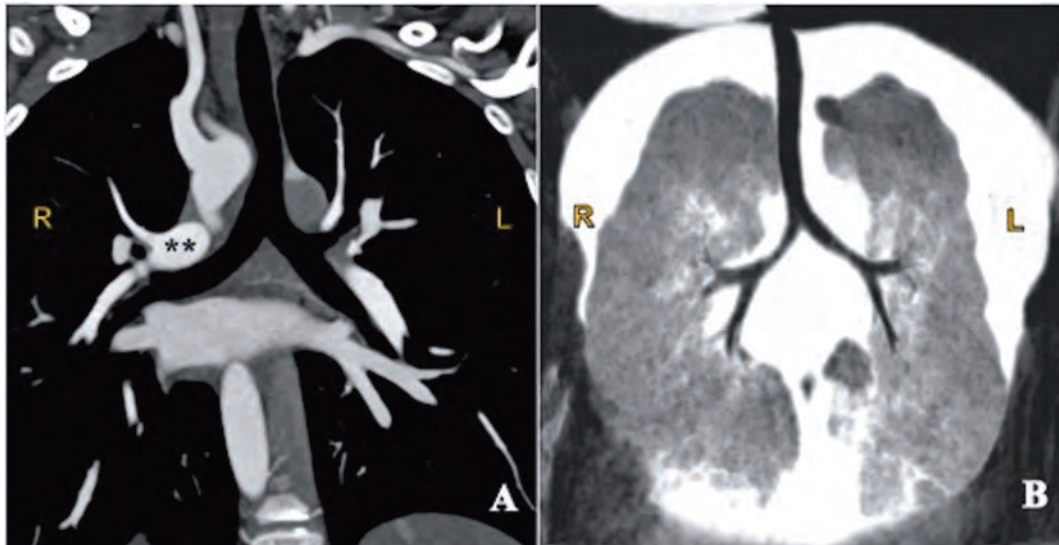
A) CT reconstruction shows right hypoarterial bronchus (). B) long bronchi, and bilobed lungs.
